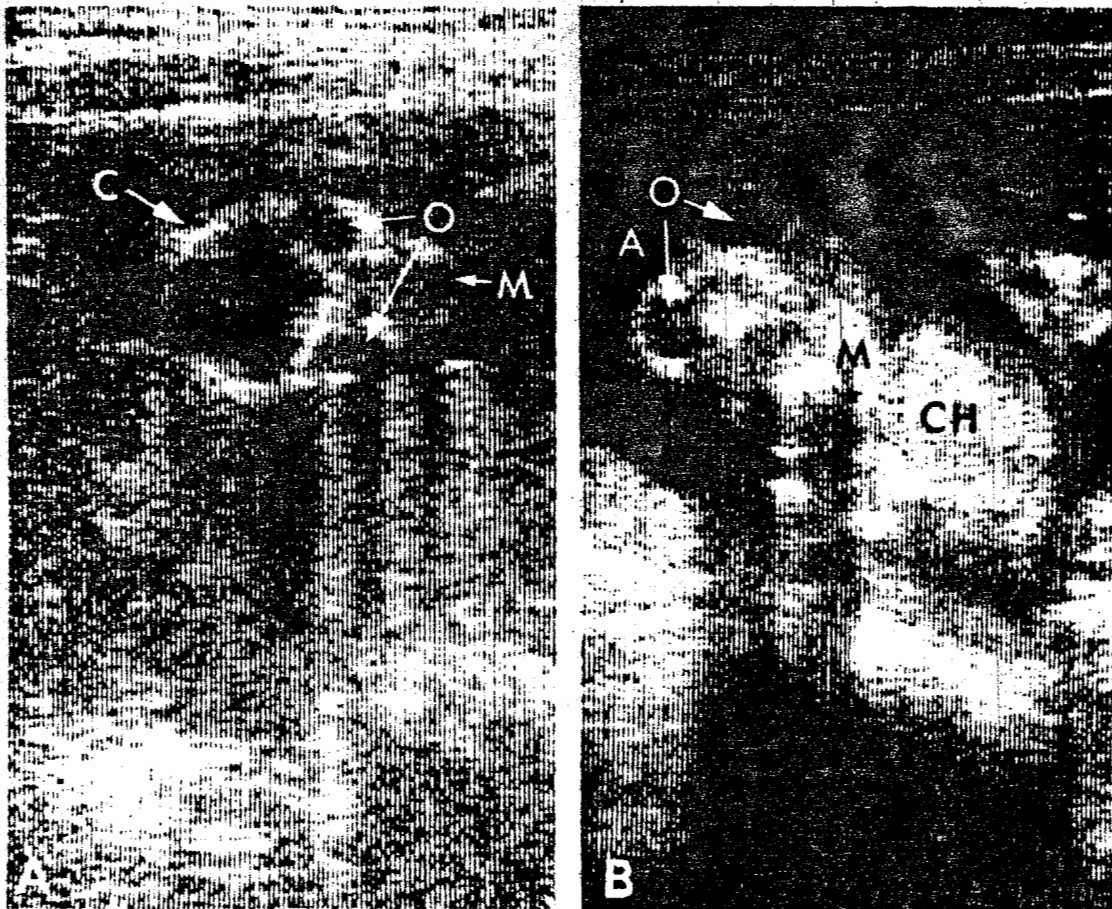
Sonogram of Normal Fetal Head (A) and of Head of Anencephalic Fetus (B).
